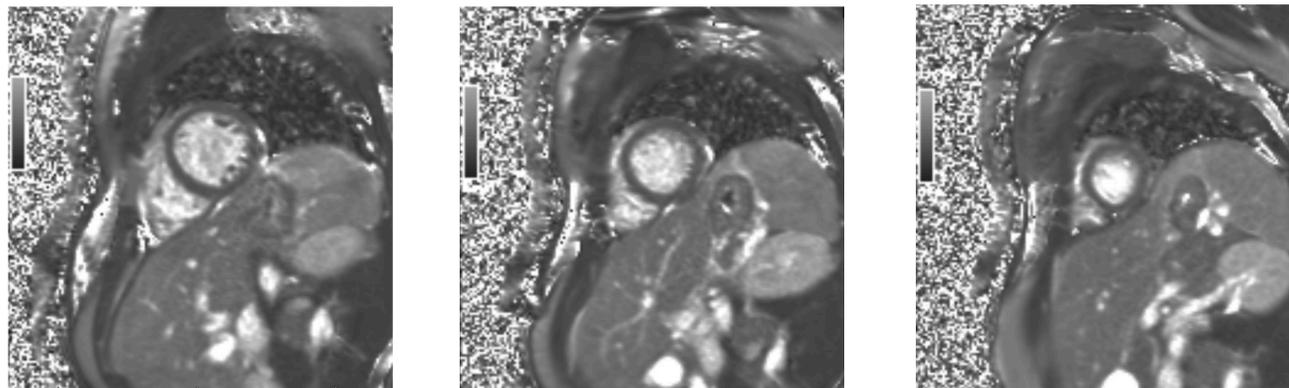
Cardiac MRI findings of borderline reduced left ventricular systolic function. On native parametric mapping T2 is elevated 54- 60 ms suggestive of myocardial edema. Atypical subepicardial enhancement noted in lateral and inferior segment(s) on late gadolinium enhanced imaging. These finding are consistent with acute myopericarditis.
